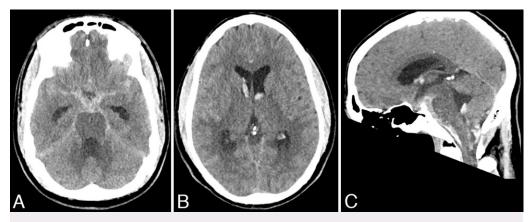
CT images, axial (A, B) and sagittal (C) views, demonstrating diffuse SAH and intraventricular hemorrhage.
